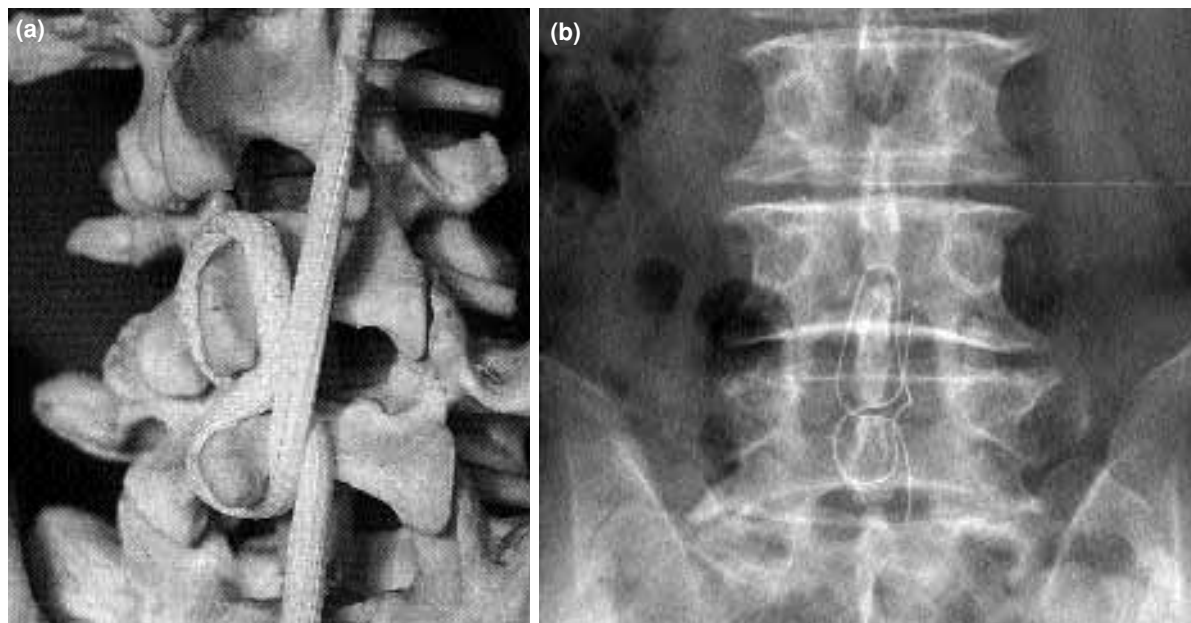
(a) The tying method of the artificial ligament and (b) its appearance on an X-ray image. The two spinous processes of L₄ and L₅ are tied together like the figure “8” with a 40-cm polyester braid artificial ligament.
